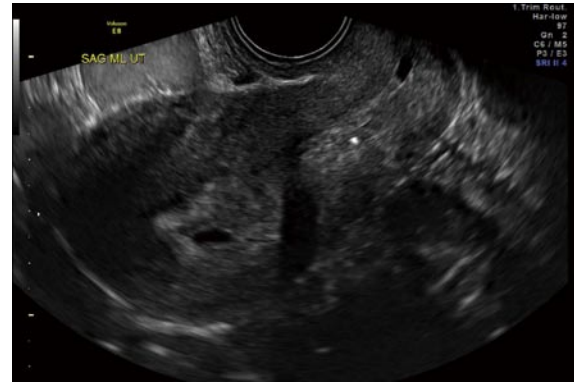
Transvaginal ultrasound image of a gestational sac consistent with an early intrauterine pregnancy.
